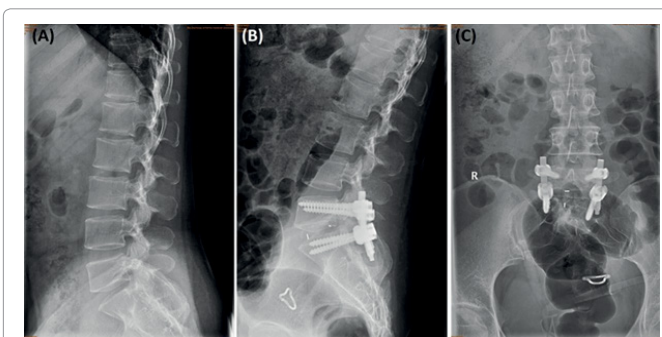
A 48 years old female with isthmic spondylolisthesis at L5-S1 level (A) Preoperative lateral radiograph showed that slippage was 31.6% and focal lordosis was -2.88. (B,C) 6 months follow-up lateral and anteroposterior X-ray showed that complete reduction of the spondylolisthesis.
